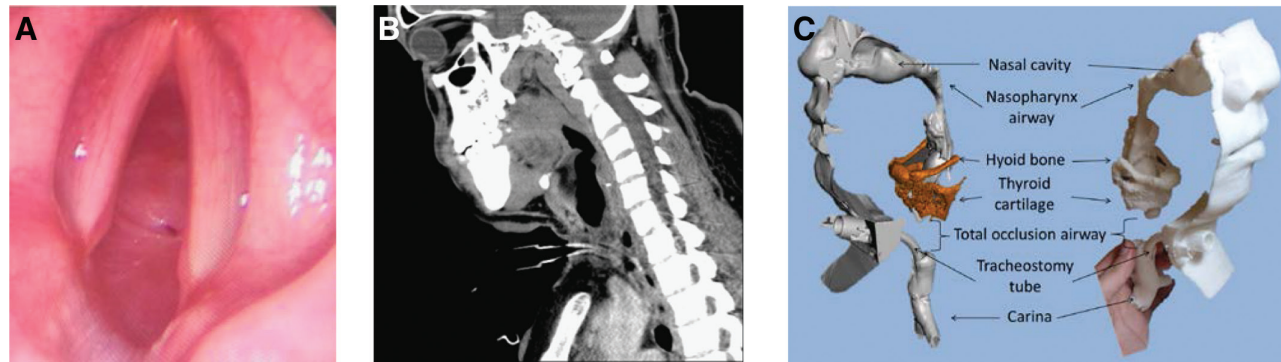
Subglottic stenosis Cotton-Myer grade IV (A) laryngoscopy, (B) neck computed tomography image. C, Reconstructed 3D model of the upper airway, the hyoid bone, and the thyroid cartilage. The left image is a computer-generated model. The right image is a 3D printed model.
